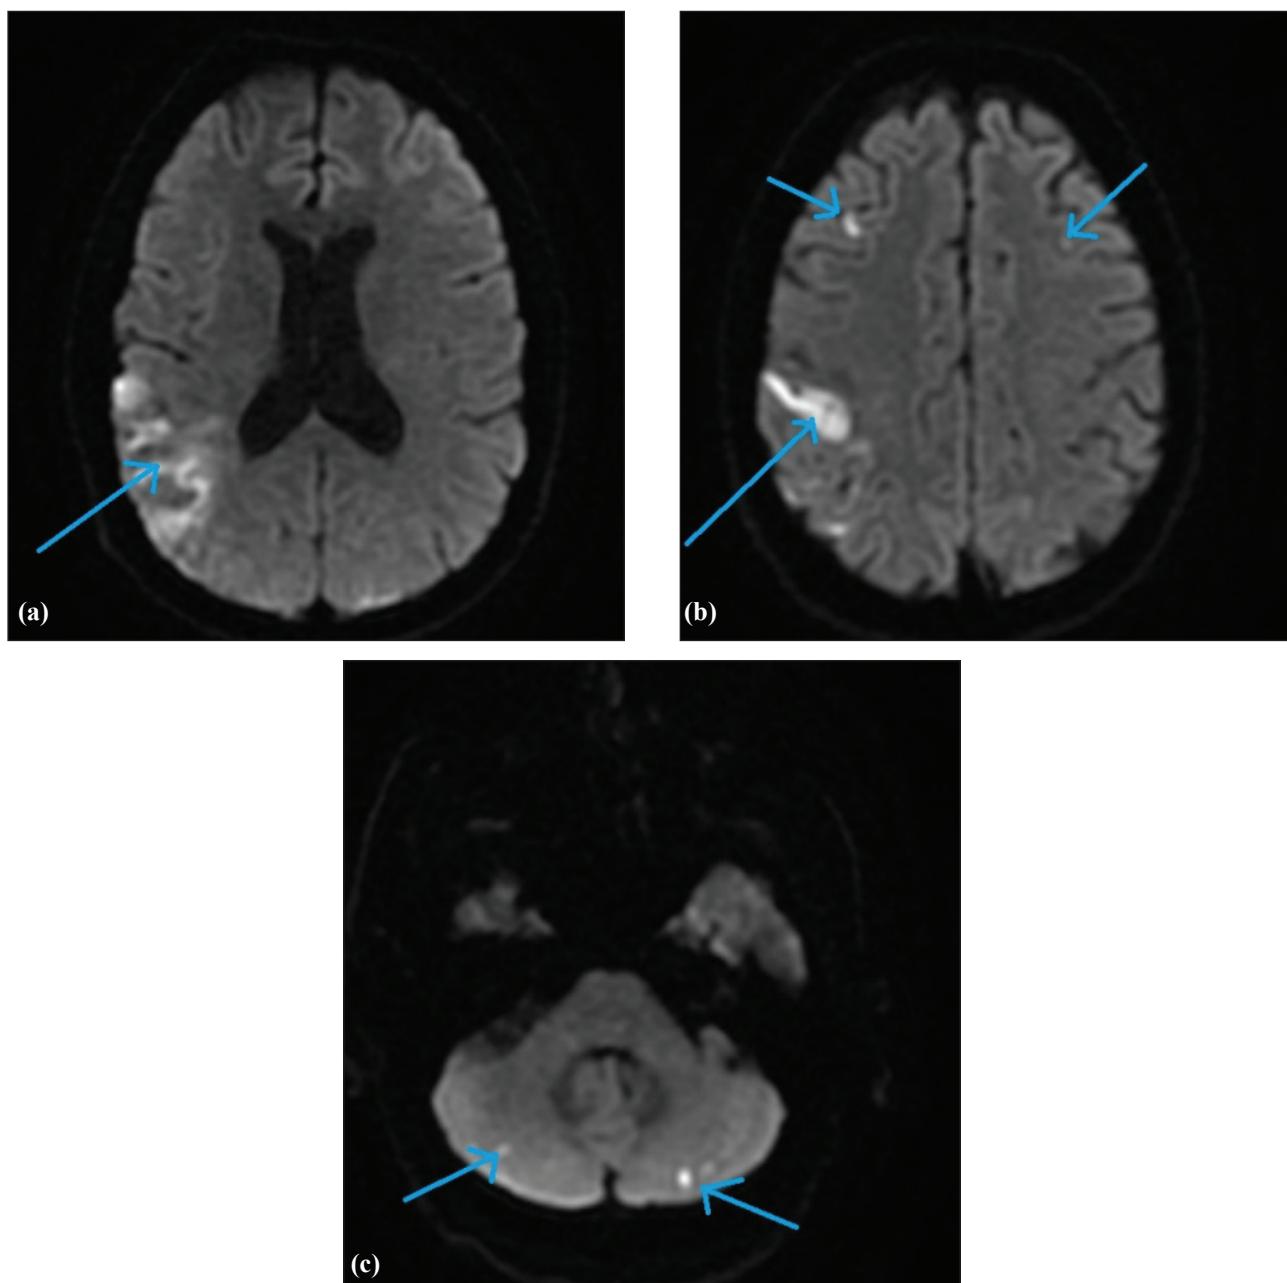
(a) MRI of the head DWI sequence: Multifocal cerebral and cerebellar infarcts with cytotoxic oedema. 167 × 184 mm (96 × 96 DPI). (b) MRI of the head DWI sequence: Multifocal cerebral and cerebellar infarcts with cytotoxic oedema. 160 × 175 mm (96 × 96 DPI). (c) MRI of the head DWI sequence: Multifocal cerebral and cerebellar infarcts with cytotoxic oedema. 165 × 165mm (96 × 96 DPI).
